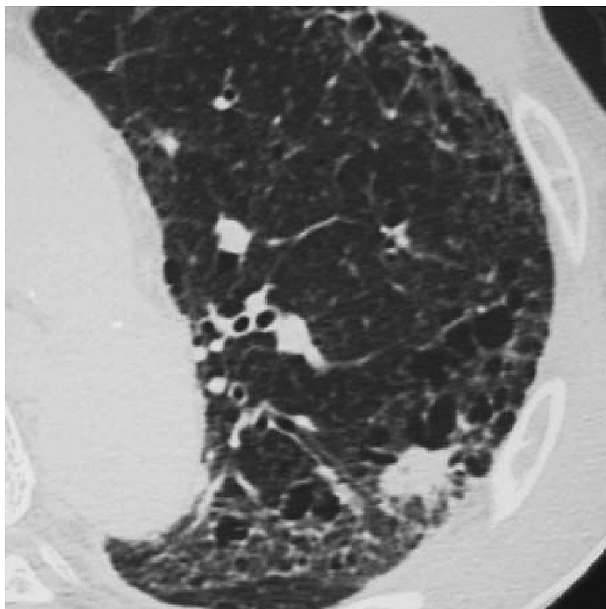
CT scan obtained in a 57-year-old man reveals an 11-mm mass with spiculation in the left upper lobe. Spiculation might be somewhat enhanced by preexisting emphysema.
